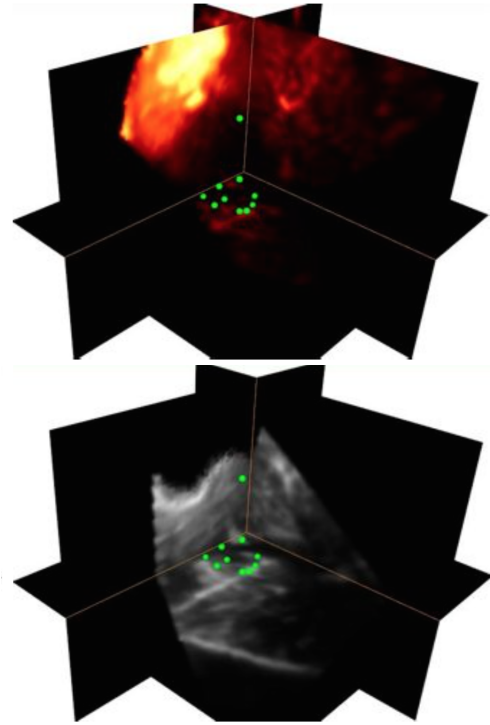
Ten corresponding landmarks in pre- (top) and post-resection (bottom) ultrasound volumes.
